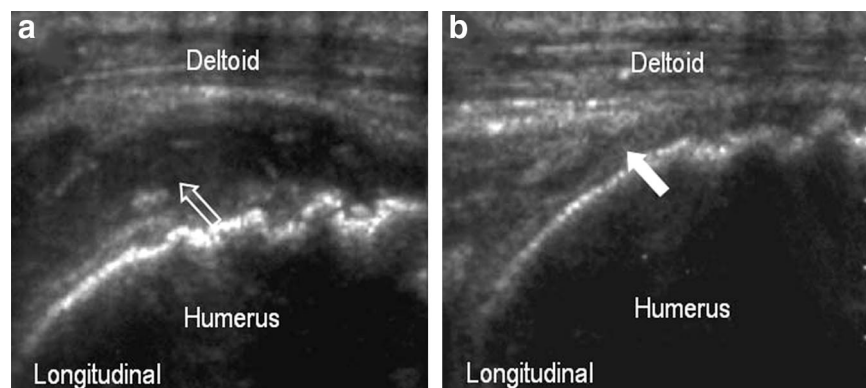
Massive tear of the rotator cuff. Longitudinal ultrasound scan showing nonvisualization of the supraspinatus tendon. a, Effusion in the space (open arrow) between the deltoid muscle and humeral head. b, Compression with the ultrasound probe obliterates (arrow) this space in between.*
